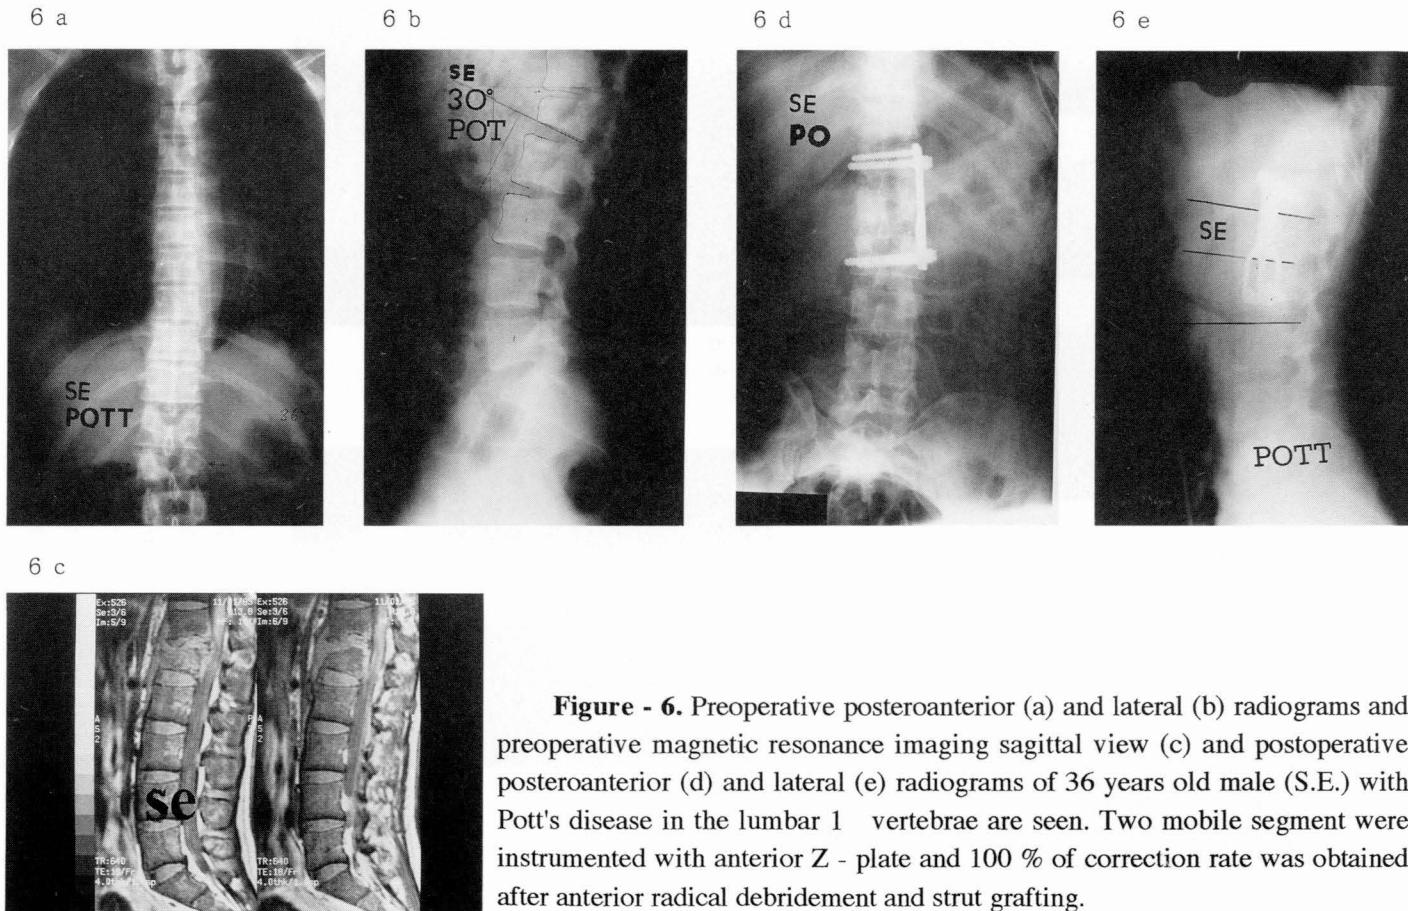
Preoperative posteroanterior (a) and lateral (b) radiographs and preoperative magnetic resonance imaging sagittal view (c) and postoperative posteroanterior (d) and lateral (e) radiographs of 36 years old male (S.E.) with Pott's disease in the lumbar 1 vertebrae are seen. Two mobile segment were instrumented with anterior Z - plate and 100 % of correction rate was obtained after anterior radical debridement and strut grafting.
